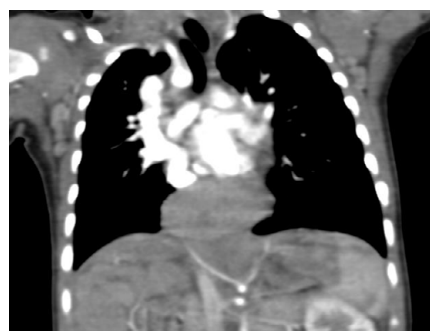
CTA coronal image) showing left sided SVC (arrow).
